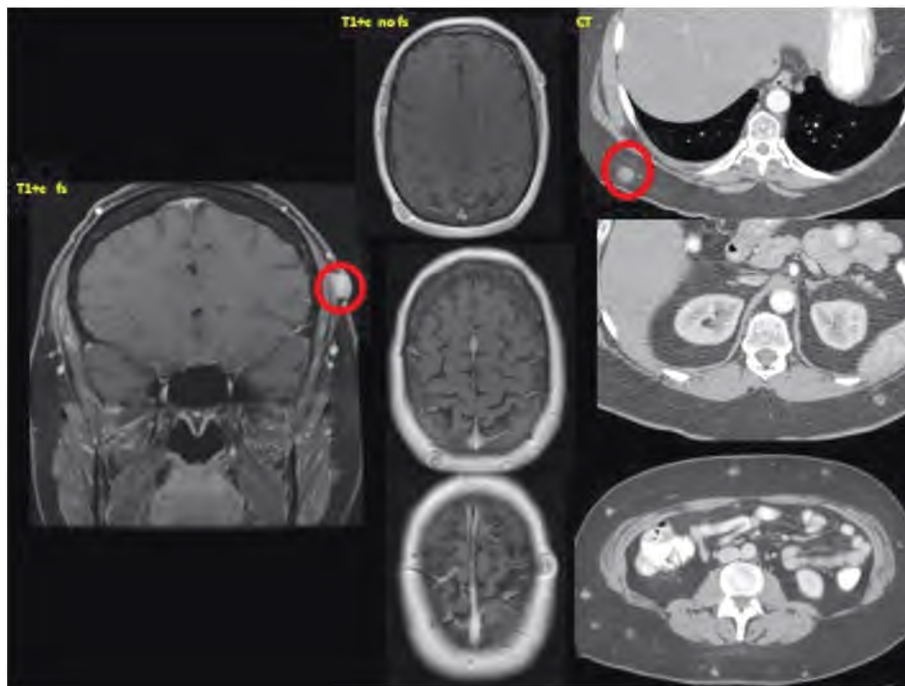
A known case of breast cancer presenting with multiple skin lesions: Post contrast MRI and CT images revealed multiple enhancing skin nodules (enhancement was perceived in mri). Pathology proved metastatic breast cancer.
